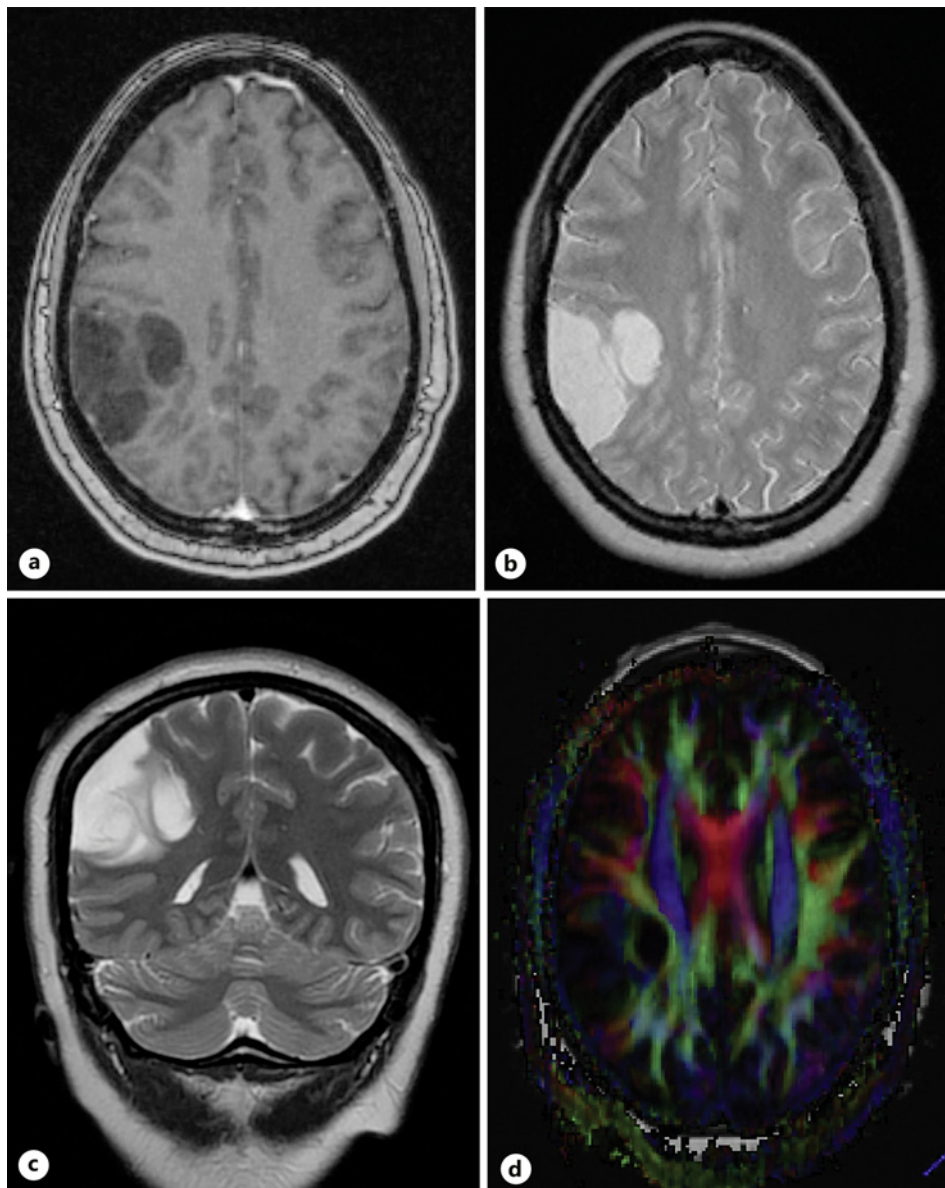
Preoperative MRI demonstrates a lobulated, cystic mass within the right parietal lobe involving the cortex and the deep white matter, associated with mild mass effect and minimal vasogenic edema. The lesion shows decreased T1 signal without contrast enhancement (a) and increased T2 signal (b, c). The lateral component measures 4.8×2.2 cm and medially as 2.2×1.4 cm. Global tractography demonstrates probable inferior and medial displacement of the right superior longitudinal fasciculus with some splaying of the fiber tracts along the medial margin of the mass, as well as medial displacement of the right corticospinal tract and mass effect upon the corpus callosum and cingulate (d).
